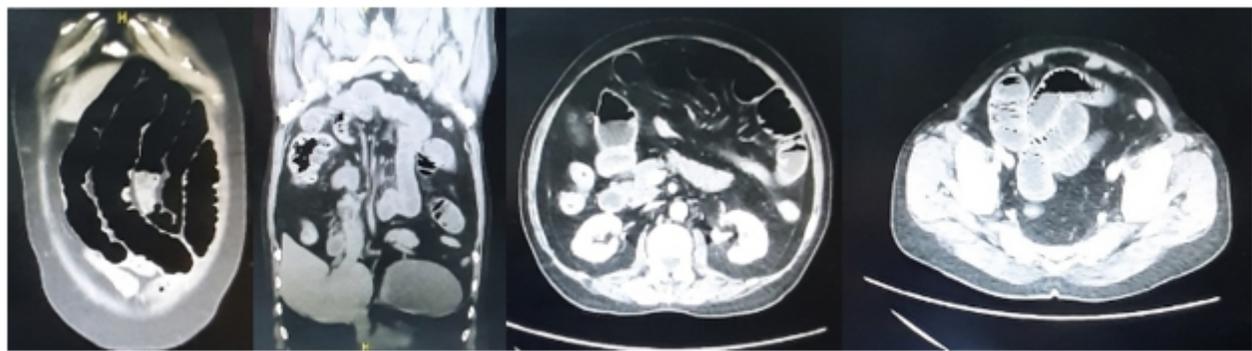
Abdominal CT showed dilated intestine without evidence of obstructive lesion.
